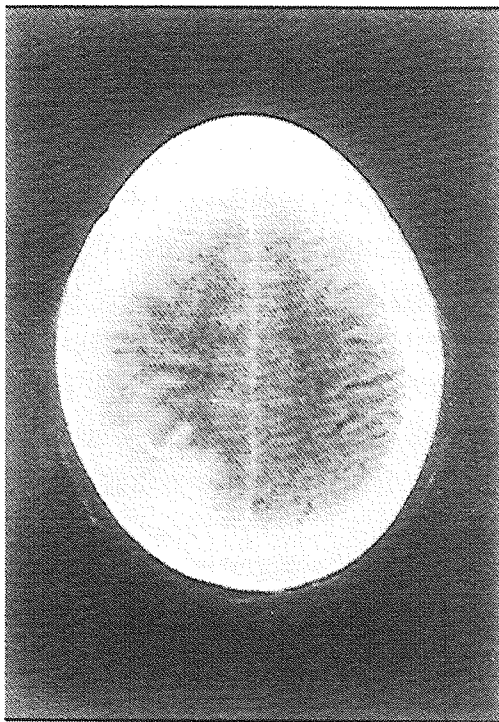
Brain CT scan in patient 1 reveals traumatic intracerebral hemorrhage in the parietal lobe in episode 2.
